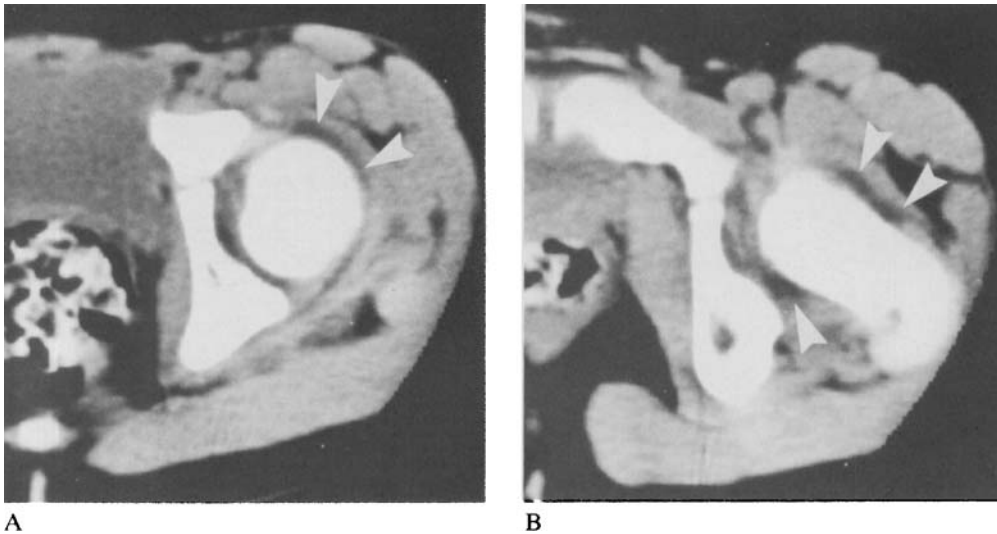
CT of a hip with effusion (arrows), at the level of the head (A) and the distal portion of the neck (B).
